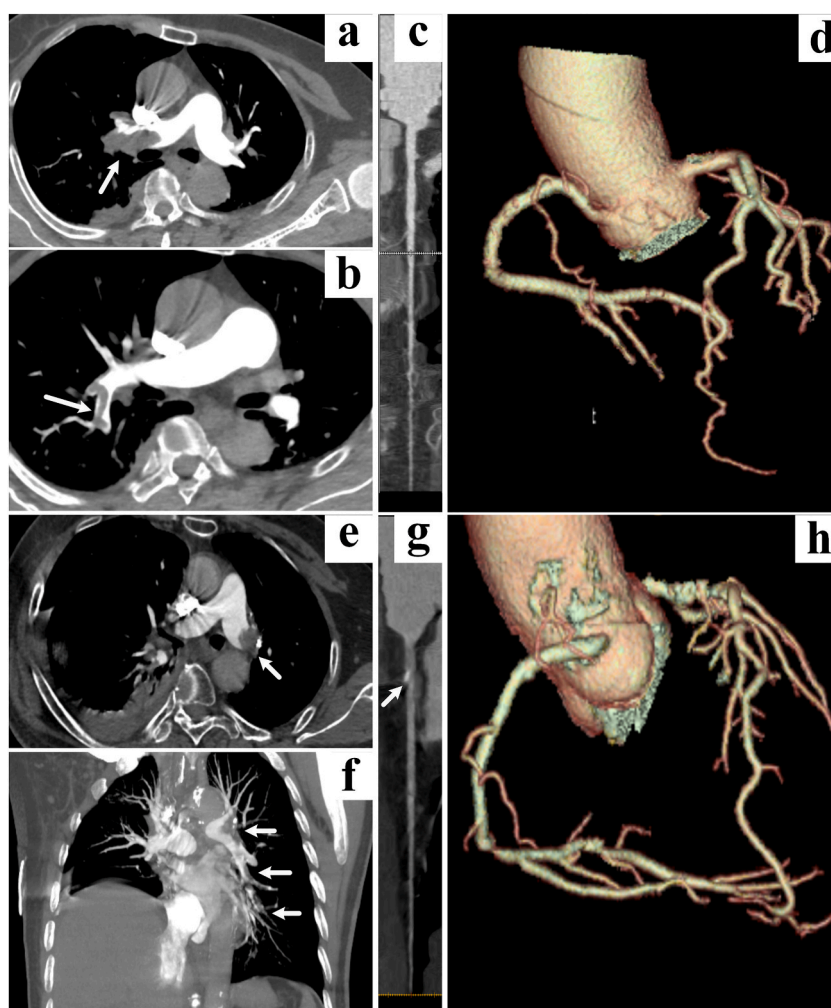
Case Studies of Pulmonary and Coronary Artery Pathologies Using Triple-Rule-Out CT Angiography (TRO CTA) a-d: A 63-year-old female, TRO CTA showed multiple pulmonary emboli in the right main pulmonary artery and its branches (indicated by arrows), demonstrating excellent visualization of the coronary vascular tree. e-f: A 68-year-old male with multiple pulmonary emboli in the left pulmonary artery (LPA) (indicated by arrows). g-h: A 75-year-old male with mixed plaque in the proximal segment of the left anterior descending artery (LAD) causing moderate stenosis (indicated by an arrow), and atherosclerosis in the ascending aorta (indicated by arrows). d and h: Volume rendering (VR) images. a, b, and e: Multiplanar reconstruction (MPR) images. f: Coronal maximum intensity projection (MIP) image. c and g: Curved planar reformation (CPR) images.
